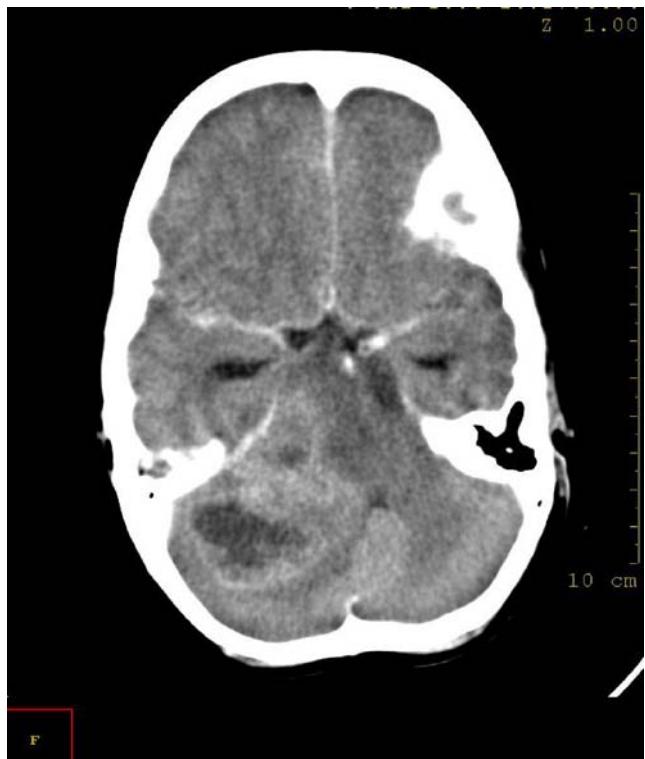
A CT scan shows a cystic tumour, with central necrosis, in the right cerebellum, expanding either from or to the brainstem, with deviation of the fourth ventricle and evident obstruction hydrocephalus
